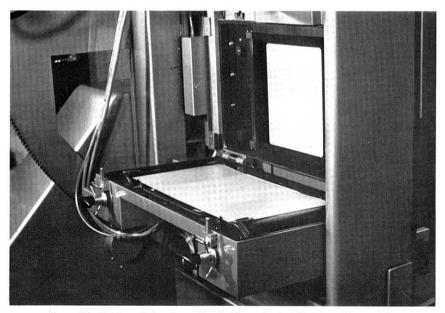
The full size roll film changer installed immediately behind the table-top of the radiographic-fluoroscopic table. The changer is open to show the inside.
